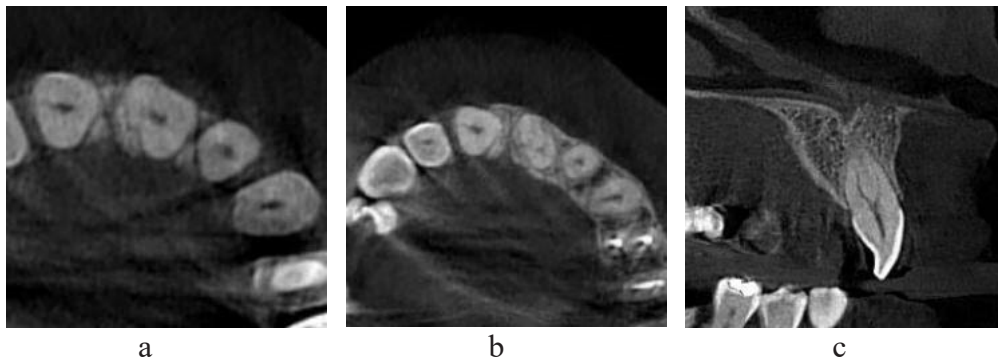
CBCT scan of the maxillary left central incisor: a) Axial view from the CEJ level, b) Axial view from mid root level and c) corrected sagittal view.
